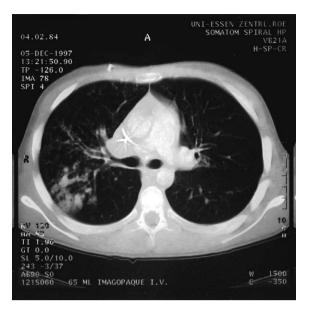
CT scan at the time of neutropenia and fever showing infiltrates in the right upper lobe.
